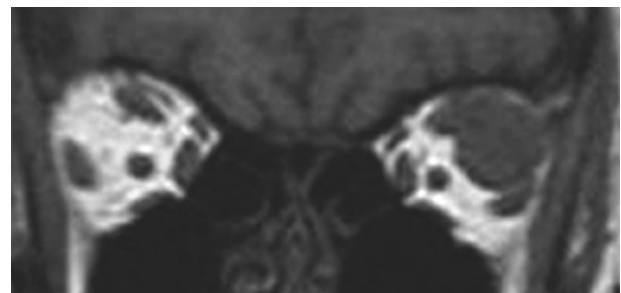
Gadolinium-enhanced T₁-weighted coronal MRI scan demonstrating a hypointense left intraconal mass abutting the lateral rectus and superior rectus muscles.
